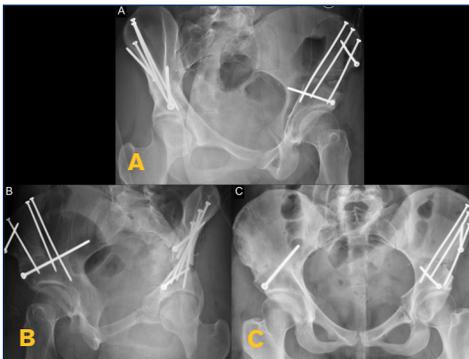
(A, B) Judet radiographs following left PAO and (C) final postoperative AP following partial hardware removal (right acetabulum). Radiographs demonstrate improved coverage of the femoral head and acceptable hardware placement.
